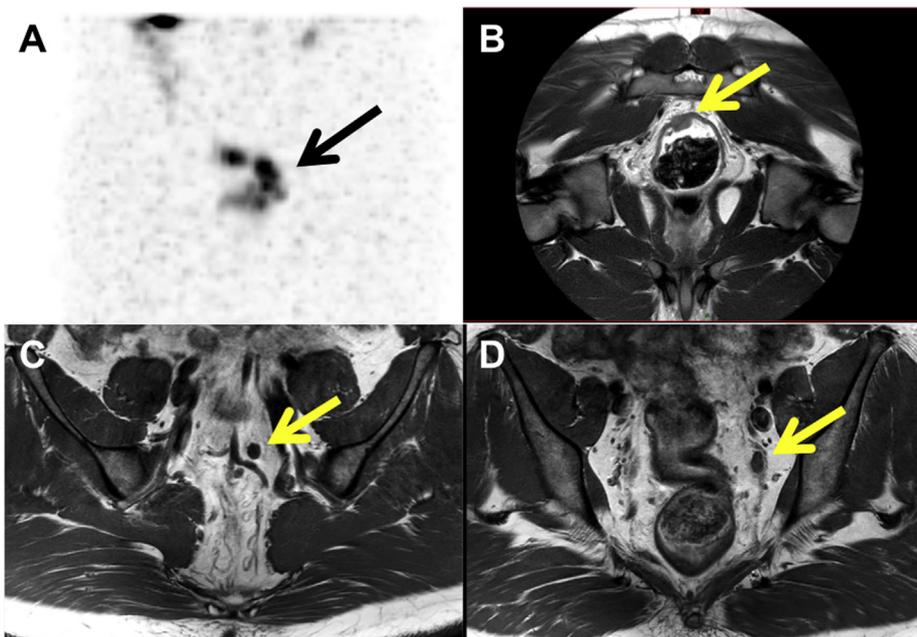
Imaging work-up of a RNET diagnosed at colonoscopy performed for rectal bleeding in a 44-year old man. A, somatostatin receptor scintigraphy showing multiple focal positivity in the rectum and the mesorectum (arrows), evocative of RNET and associated lymph-node metastases. B, sagittal T2-weighted pelvic MRI showing a 20 × 11 × 14 mm tumor (arrow) localized at 11 cm from anal verge, invading the muscularis propria and the mesorectum. C-D, axial T1-weighted pelvic MRI showing two enlarged (8 mm of small axis) lymph nodes suspect of metastatic spreading.
